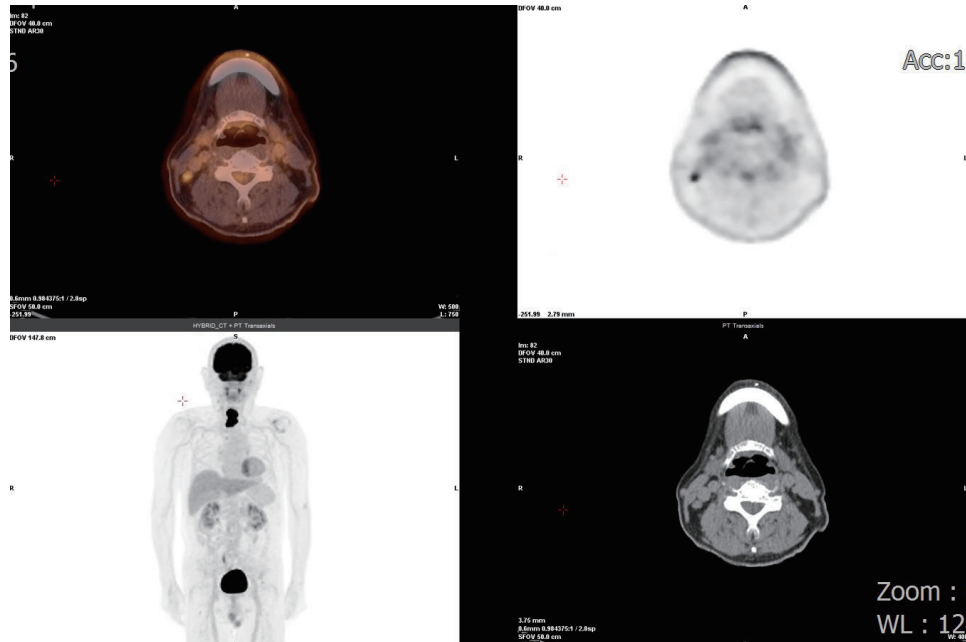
圖三 在正子電腦斷層造影掃描中，影像顯示 ^{18}F -FDG 葡萄糖異常活度吸收涉及上頸食道。
